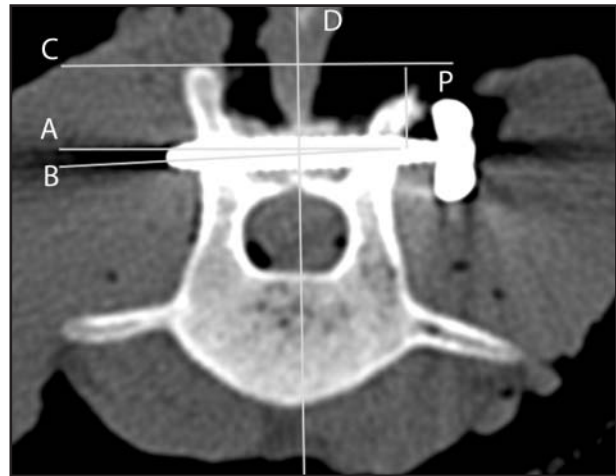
A CT image of measurement of the angle of the screw inserted through the facets of L1. A horizontal line (line C) passes through the dorsal rim of the facets. The angle between the line (line B) that passes through the middle of the screw and a horizontal line (line A) that is parallel to line C is the angle of insertion. For the measurements, a vertical line (line D) has been drawn to provide a better orientation and to ensure that line A and C are both perpendicular to line D. Angle of insertion is 2.97° . Line P represents the distance from the dorsal border of the facet joint to the center of the screw.
